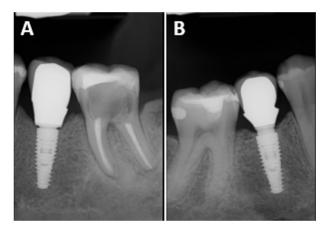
A) and B) Periapical x-rays of regions 35 and 45 at the one-year follow-up.
